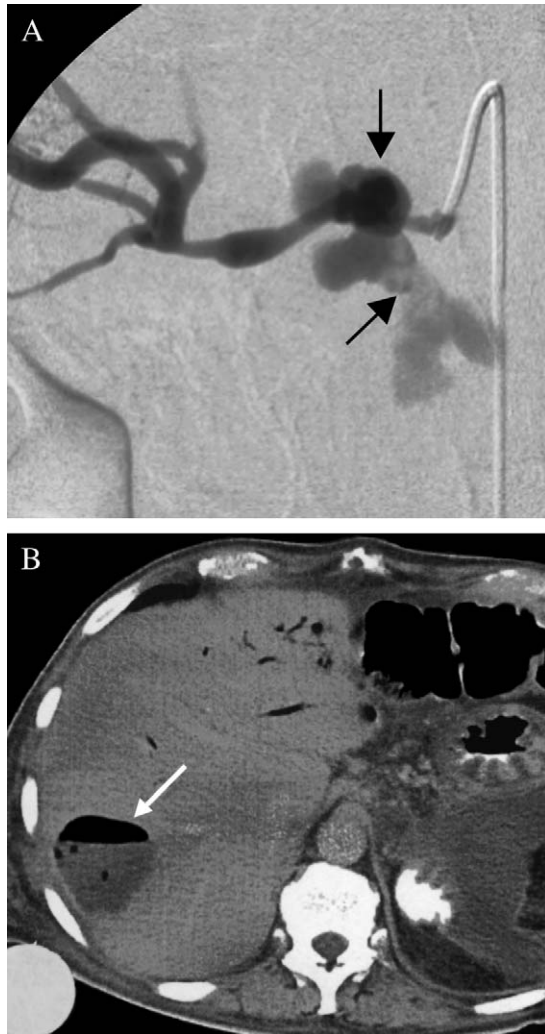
(A) Bleeding originating from the common hepatic artery (arrows) 26 days after pylorus-preserving pancreatoduodenectomy for cancer of the pancreatic head. The bleeding was subsequently controlled by coil embolization of the common hepatic artery, but the patient had no arterial collaterals to the liver. (B) CT scan of the same patient three weeks after angiographic bleeding control showing an intrahepatic abscess (arrow) that was successfully treated by CT-guided drainage.
